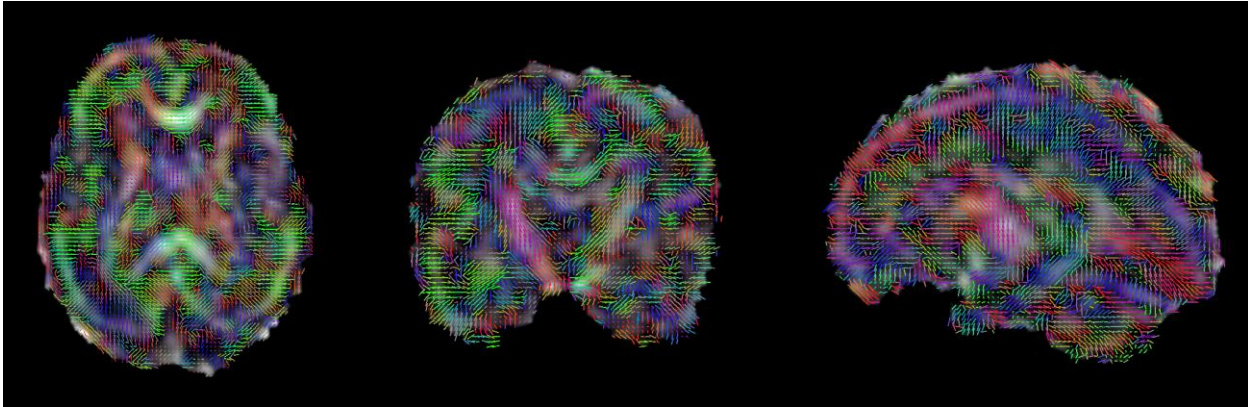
Axial, coronal and sagittal slices of the fractional anisotropy map of a fetal brain after dynamic distortion and motion correction of a x week fetus acquired on a 3T MRI scanner. These results show high anisotropy in the cortex and maturing white matter structures such as the splenium, as expected in early brain development.
